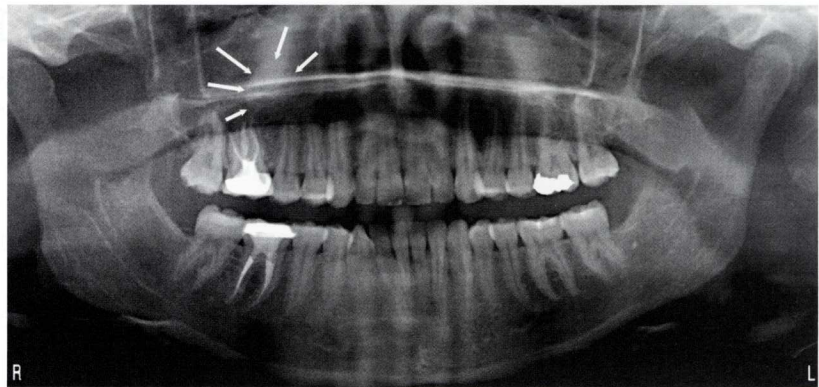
Panoramic radiograph of the same patient shown in Figure 1, taken one year after the original biopsy. It shows a typical dome-shaped antral pseudocyst in the right maxillary sinus (white arrows). No evidence of the previous antral pseudocyst in the left sinus is seen.
